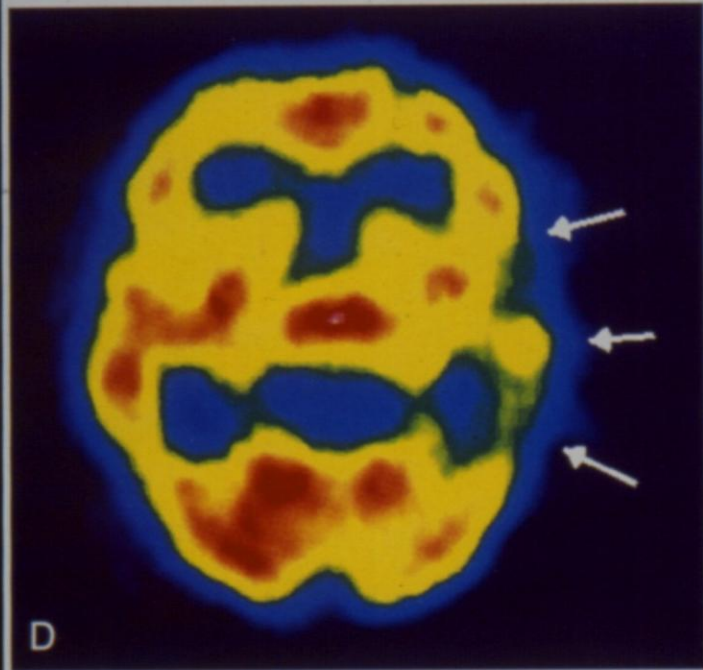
Interictal SPECT cerebral perfusion examination using HMPAO in a patient with medically intractable partial complex epilepsy. The selected transaxial and coronal planes demonstrate hypoperfusion of the left temporal lobe.
